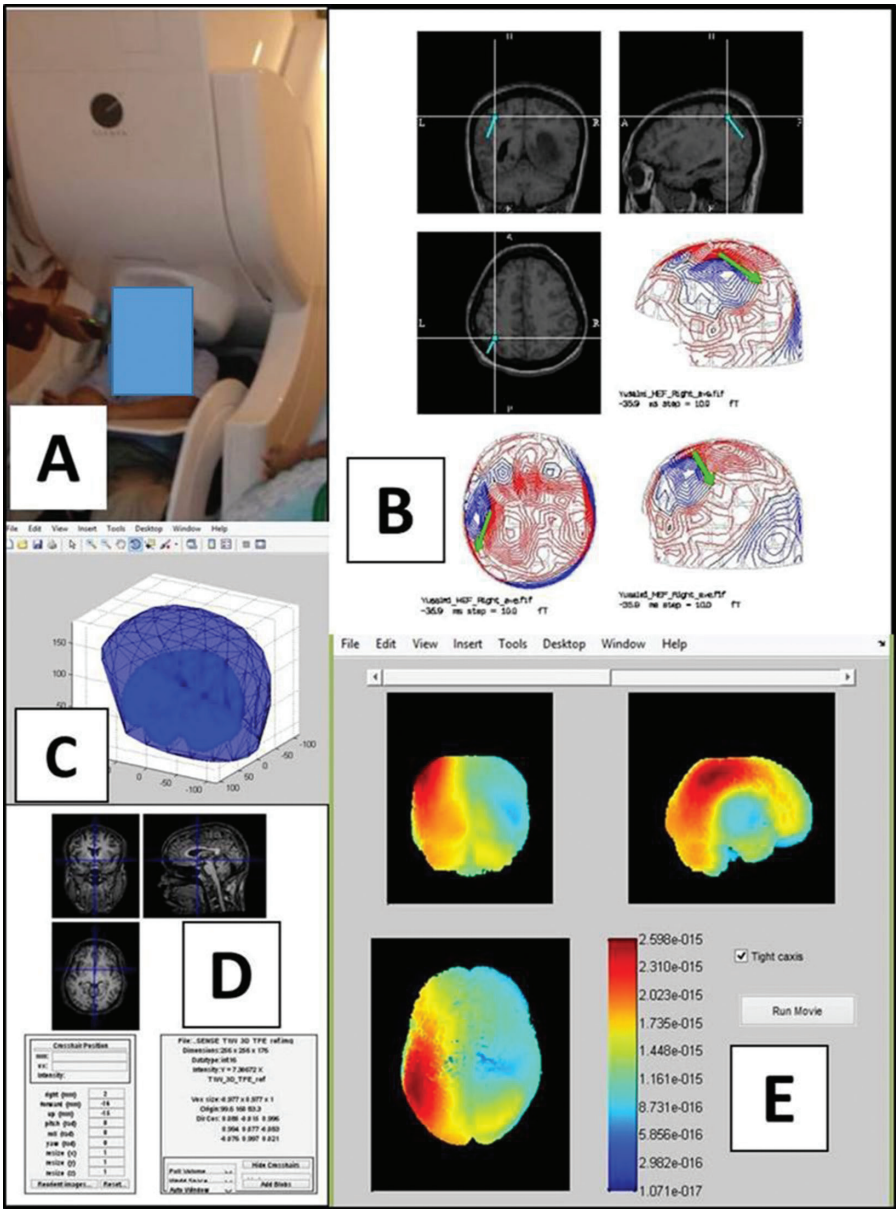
(A) MEG recording procedure. (B) An overdetermined equivalent current dipoles analysis using the vector of magnetic fields to localize the source of various evoked fields. (C) Spherical modelling for the brain using Matlab. (D) Image fusion between MEG-brainwave and MRI brain. (E) Underdetermined inverse solutions using Matlab for MEG data that have a significant response to the evoked magnetic field (in this example, it is the somatosensory-evoked field).
